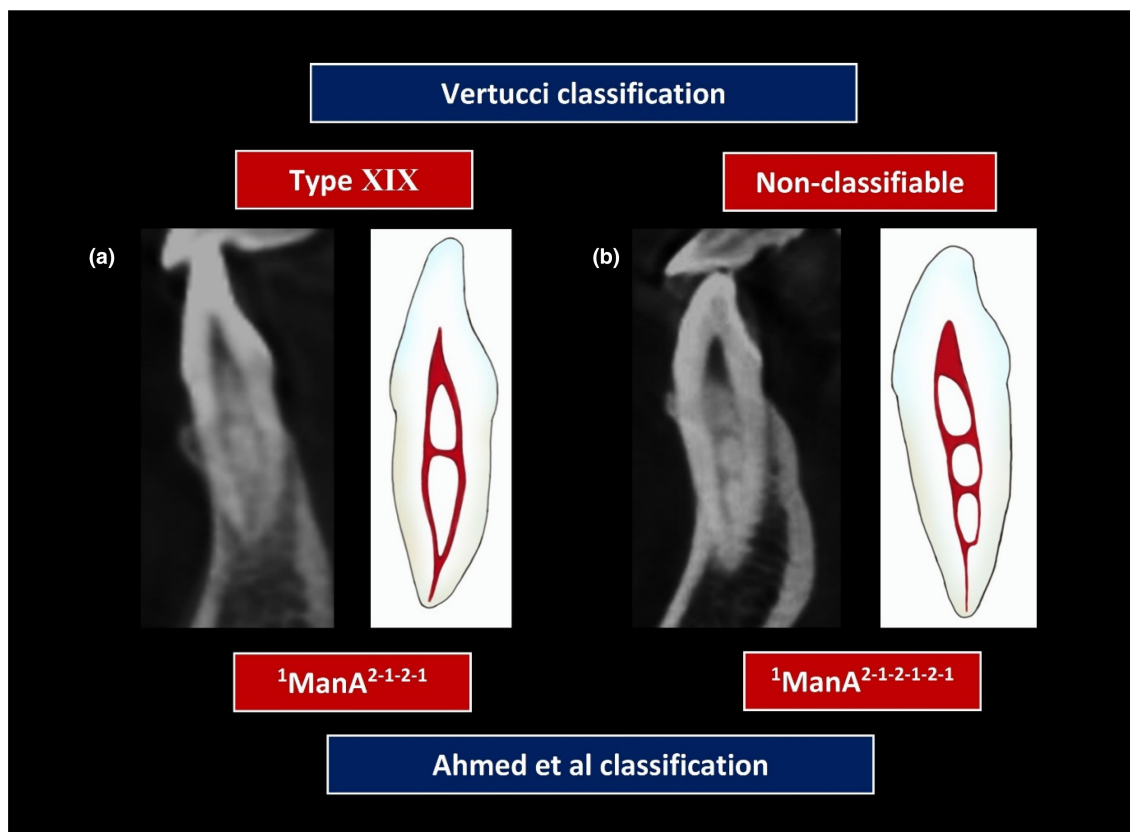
Cone beam computed tomography images showing Vertucci type XIX and non-classifiable teeth which were classified using the Ahmed et al. system as ${}^1\text{ManA}^{2-1-2-1}$ (a), and ${}^1\text{ManA}^{2-1-2-1-2-1}$ (b), respectively. Reproduced and modified from Karobari et al. [21, 34] with permission.
